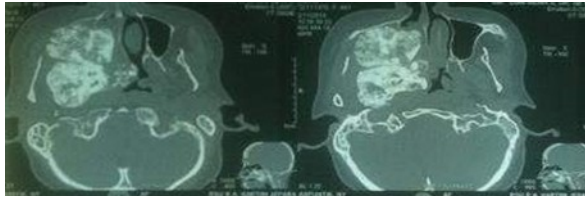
Example CT-scan of Paranasal Sinus Cavities with axial contrast cut
